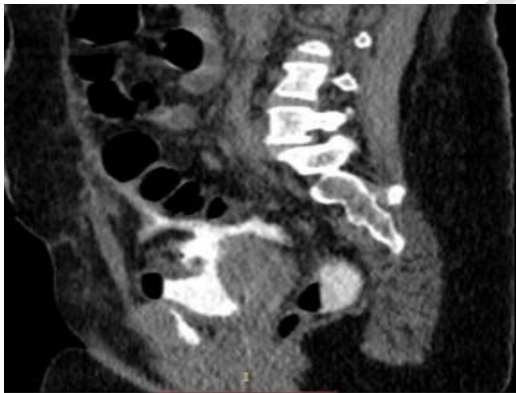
A: Axial CT cystogram image showing the extravasated contrast around the bowel loops indicated intraperitoneal rupture, B: Sagittal CT cystogram image showing intraperitoneal contrast extravasation from a small defect on the urinary bladder dome with tip of foleys catheter passing through the defect.
